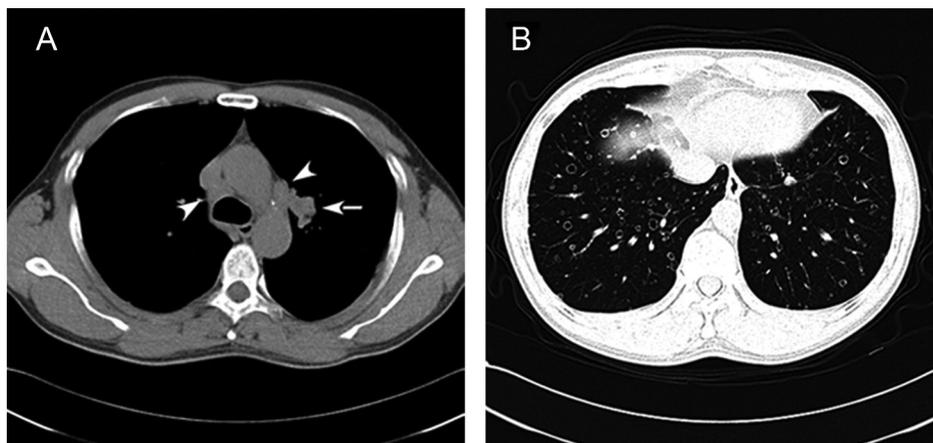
A, Initial chest computed tomography showed a 25×20 mm central located mass in the left upper lobe with hilar lymphadenopathy. B, Diffused cystic lesions in bilateral lungs.
